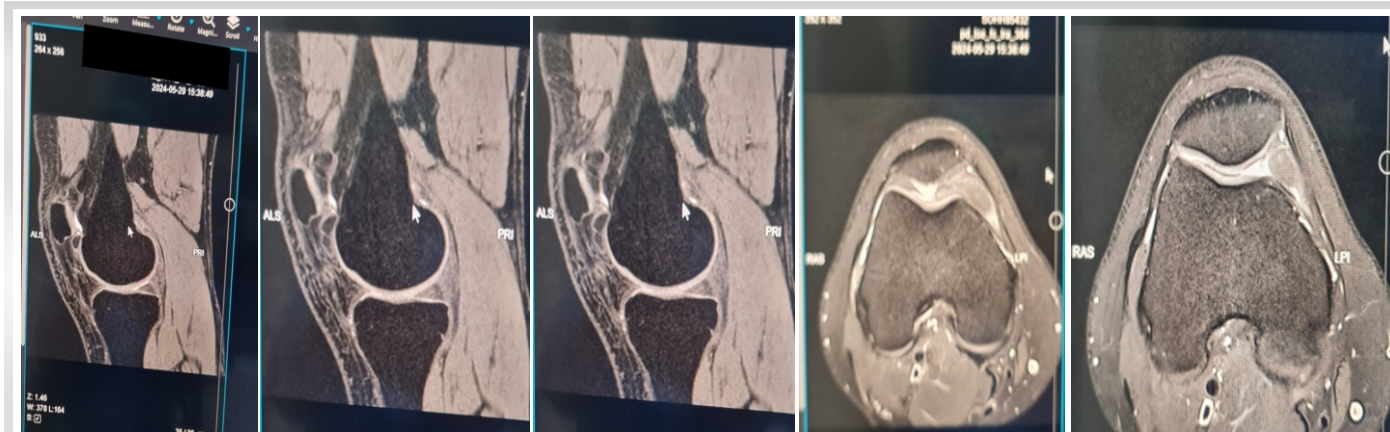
Sagittal magnetic resonance imaging (T1-weighted) images showing a hyperintense intra-articular mass in the inferomedial recess.
